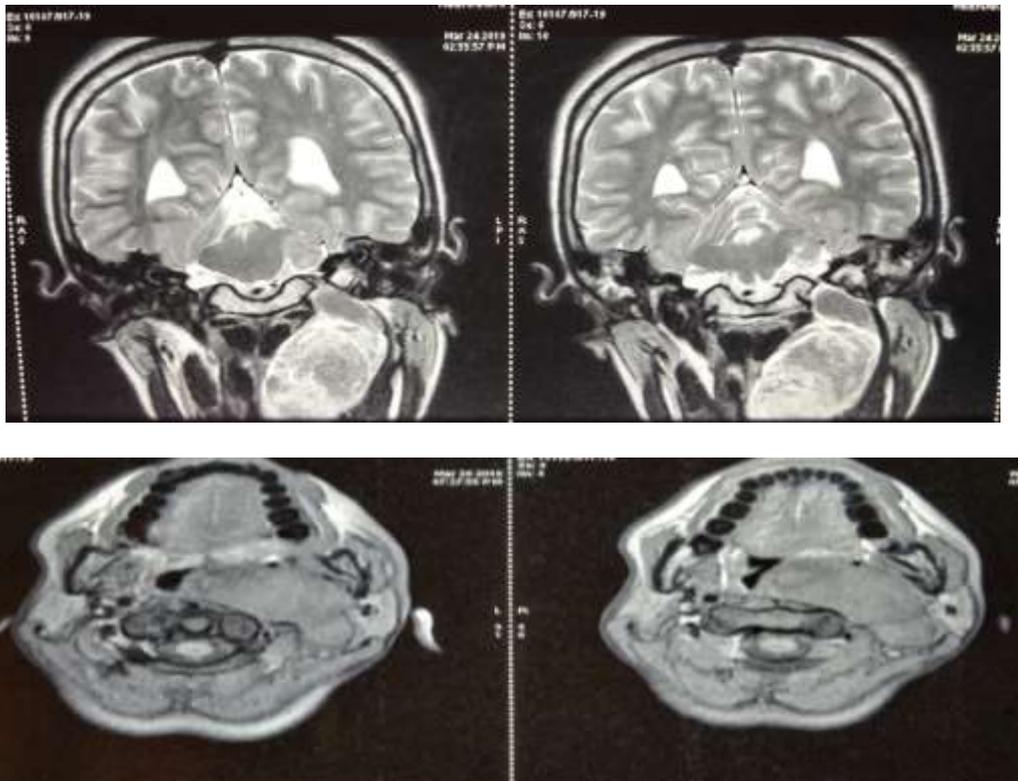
MRI images showing lesion in the left parapharyngeal space with extension into carotid space and oropharynx.
